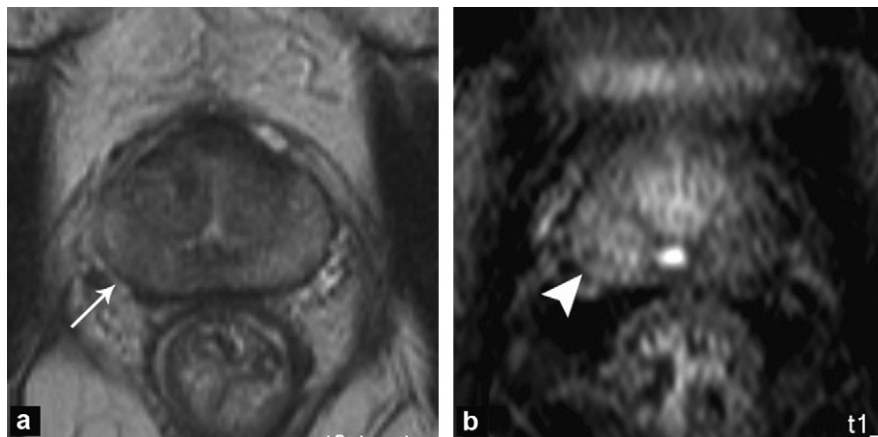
A 65-year-old patient treated with radio-hormonal therapy 4 years previously for a Gleason 6 prostatic adenocarcinoma with a PSA of 20 ng/mL. The PSA nadir was 0.1 ng/mL and the level gradually climbed again to 3.5 ng/mL: a: T2-weighted axial magnetic resonance imaging (MRI) shows a discrete hypointense area in the right mid part of the peripheral zone (arrow); b: the dynamic axial slice after contrast agent injection shows early enhancement of the entire right mid part (arrowhead). Biopsies showed a Gleason 7 prostatic adenocarcinoma of the right mid part.
